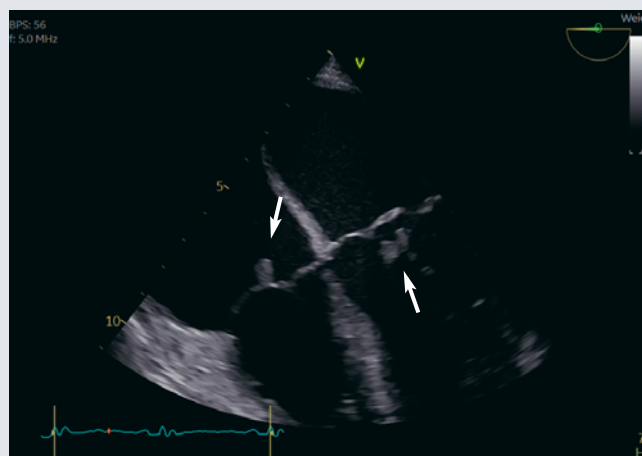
Transesophageal echocardiography showing hypoechoic, mobile structures on the mitral (right arrow) and tricuspid (left arrow) valves, consistent with vegetations in the setting of infective endocarditis.
